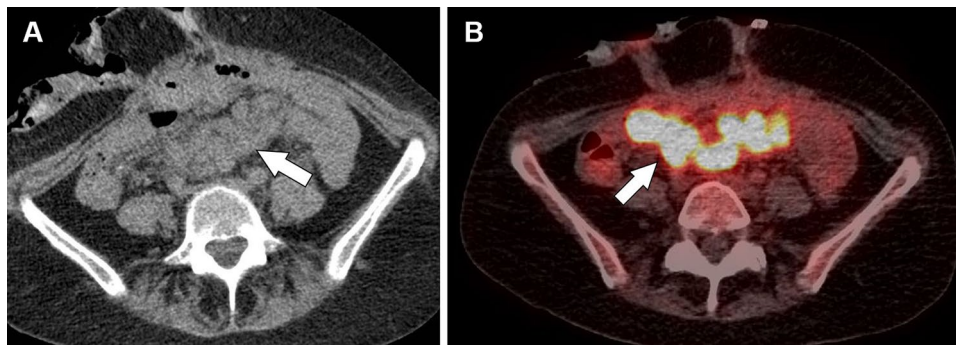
Axial non-contrast CT at the level of mid abdomen (a) in a patient who underwent IIT approximately 4 months earlier, demonstrating bulky lymphadenopathy along the transplant mesentery (arrow, a). Axial image from fused PET-CT at level of mid abdomen
